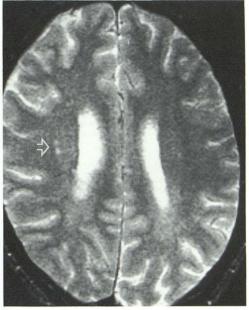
A*, Punctate focus of increased T2 signal (*arrow*) is visualized in the left frontal white matter in this 29-year-old HIV(+) subject. These findings, present in 43% of HIV(+) and 33% of HIV(-) subjects, were isointense on T1-weighted images and hyperintense on T2-weighted images.
